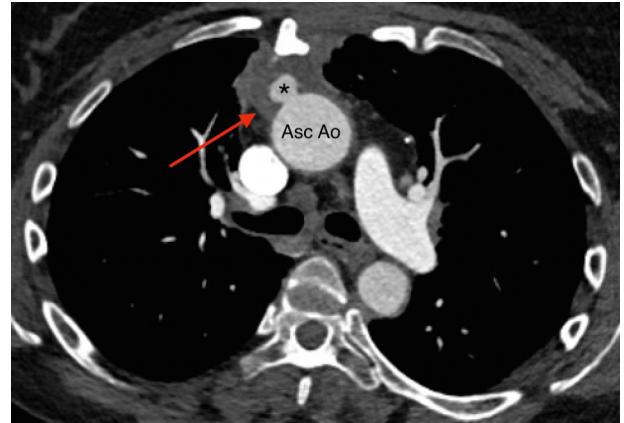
Chest CT with transverse view showing the pseudoaneurysm (asterisk) in the ascending aorta with surrounding soft tissue thickening (arrow). Asc Ao, Ascending aorta.
